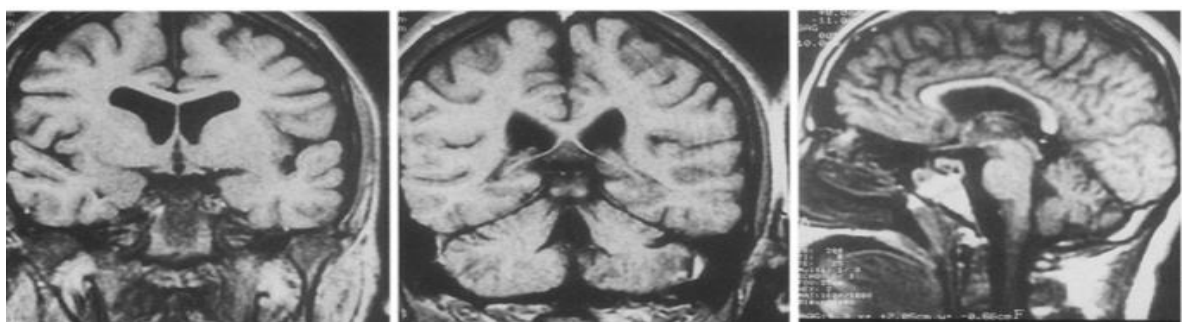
MRI scan of NPC patient brain showing cerebral atrophy, and hypoplasia of corpus callosum (Fink *et al.*, 1989).
